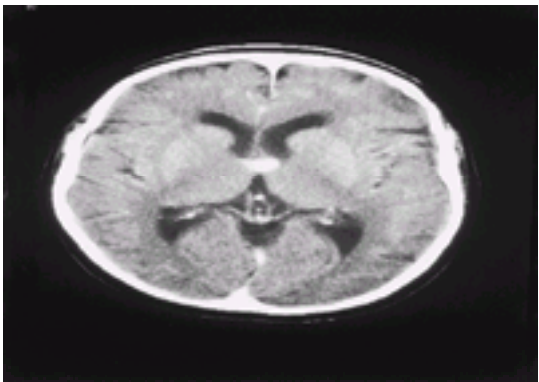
CT scan showing a typical hyperdense colloid cyst of the third ventricle causing hydrocephalus. The patient presented having had five episodes of unconsciousness due to sudden hydrocephalic attacks from intermittent raised intracranial pressure.
